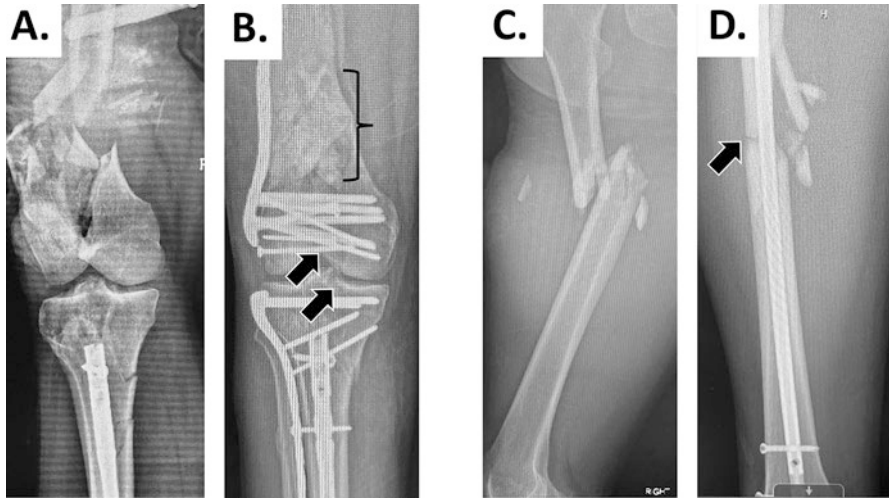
Type of bone healing is dependent upon fixation and extent of injury. Radiographs of a patient injured in a motor vehicle collision with open, comminuted, and displaced intra-articular fracture of the distal femur with severe metaphyseal comminution and bone loss before (a) and after (b) surgical fixation. There was also a minimally displaced intra-articular fracture of the proximal tibia. The intra-articular fractures of the femur (and tibia) are fixed with high stability (plate and screws) after near anatomic reduction and are expected to heal via primary bone healing (black arrows), akin to intramembranous bone formation. The metaphyseal bone loss is fixed with “relative stability” using a spanning plate and because it is a critical sized defect will undergo a bone grafting procedure (induced membrane technique) for eventual healing via a process permissive of endochondral bone formation (bracket). (c, d) Radiographs of a second patient injured in a motor vehicle collision with open, comminuted, and displaced fracture of the femoral diaphysis. Fractures of the shaft are fixated with “relative stability” (intramedullary nail) after reduction of length-alignment-rotation and expected to heal via secondary bone healing akin to endochondral bone formation. A radiographically visible callus would be expected in this mode of healing
